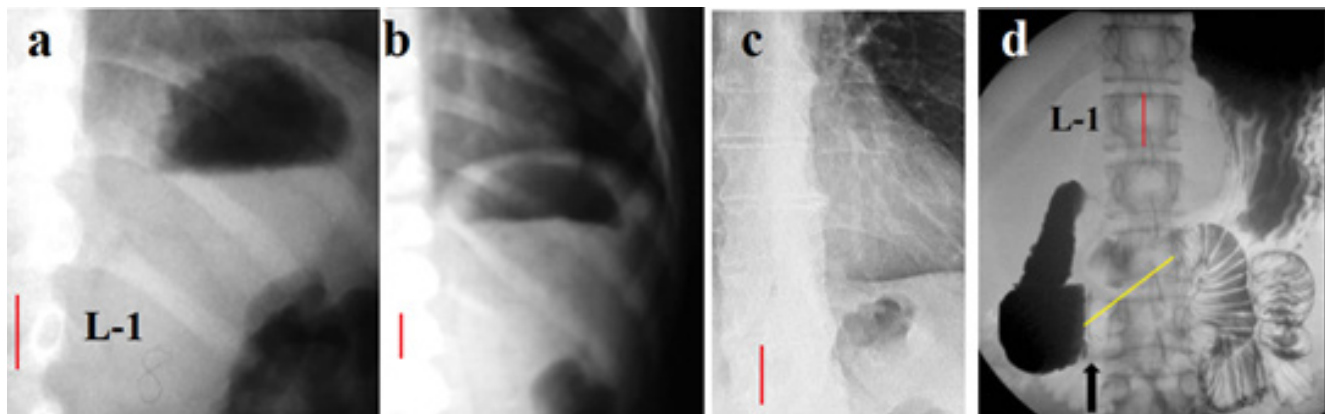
Radiographs with GGB. (a). An 8-month-old patient. (b). An 8-year-old patient. The size of the GGB in both images seems to be the same. However, the true magnitude of the GGB in figure (b) is smaller because the images were taken with different projection magnifications. (c). In the radiograph of a 56-year-old patient with GERD symptoms, the GGB is very small. (d). In the radiograph, the yellow line shows the contraction of the Ochsner sphincter. The image shows that a significant volume of gas is evacuated from the stomach into the jejunum.
